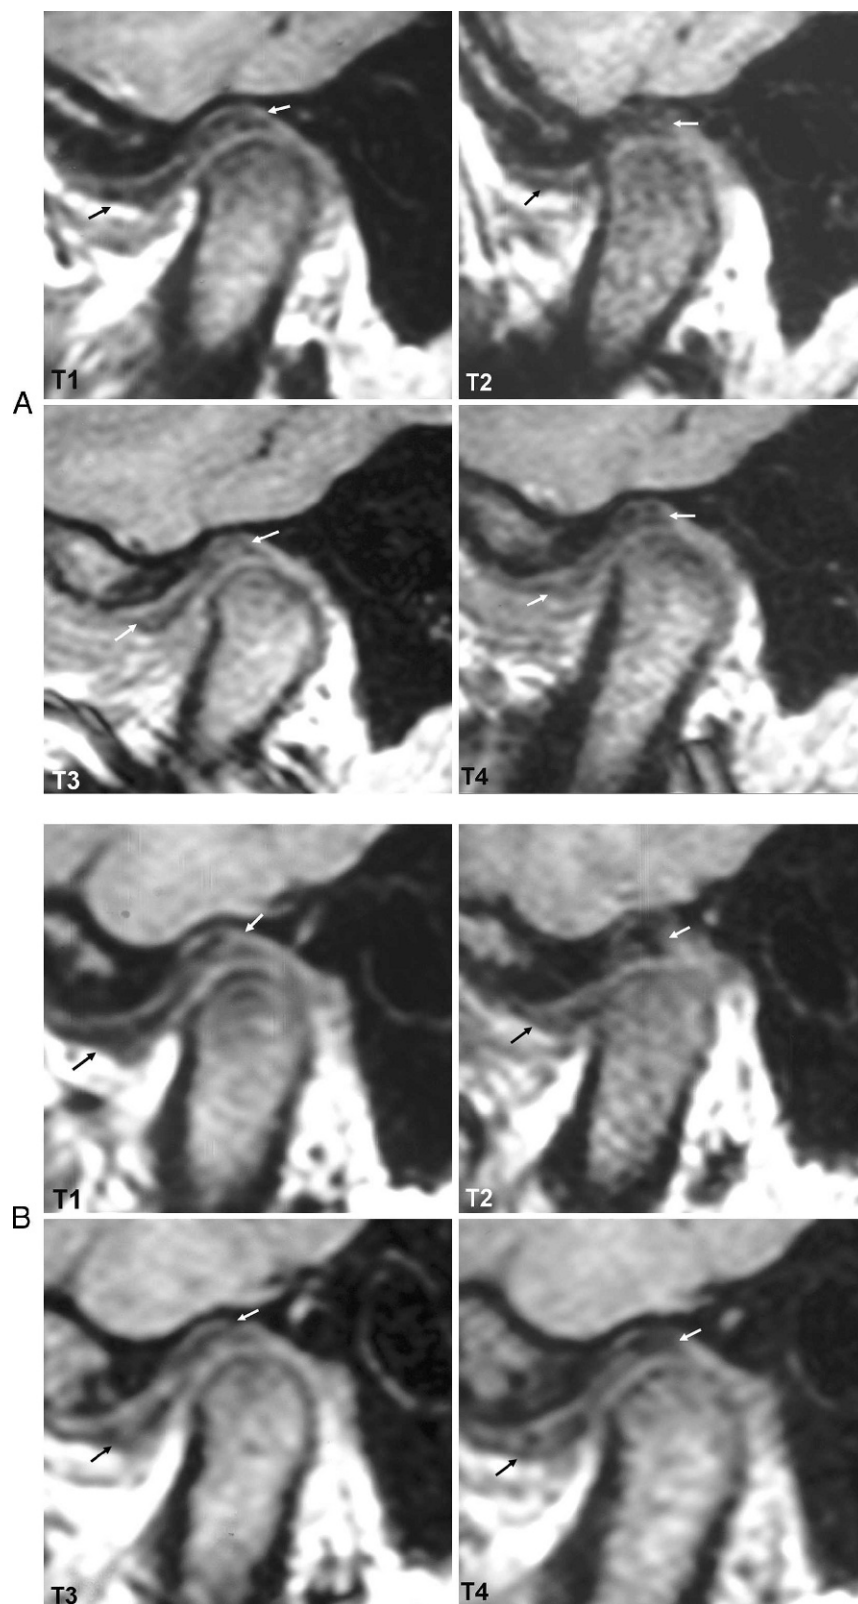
Case 9. Left (A) and right (B) temporomandibular joint magnetic resonance images (mouth closed). The disc is in its normal superior position at T1, T3, and T4, showing a retrusive tendency at T2. The disc form is biconcave.
